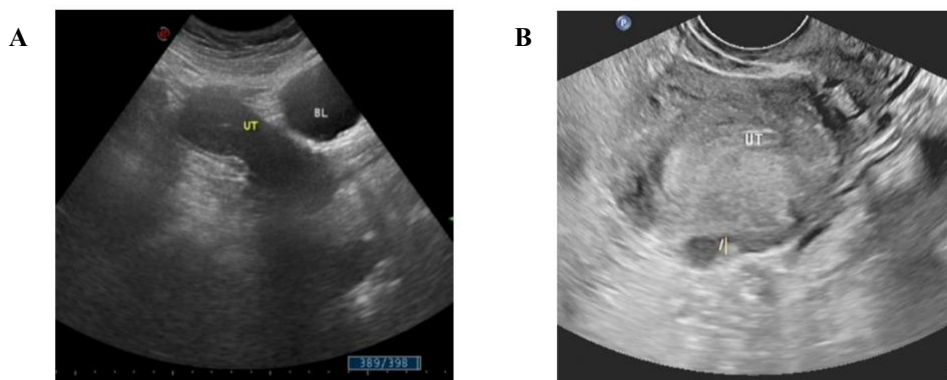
Ultrasound images of the uterus; (A) No uterine fibroids were found during ultrasound examination in November 2017; (B) Fibroids were found in the posterior wall of the uterus in March 2020
